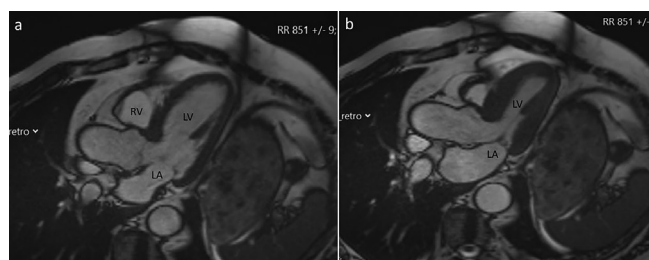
(a) Cardiac magnetic resonance imaging in the horizontal axis showing the left ventricle during the diastolic phase. (b) Cardiac magnetic resonance imaging in the horizontal axis showing the left ventricle during the systolic phase
